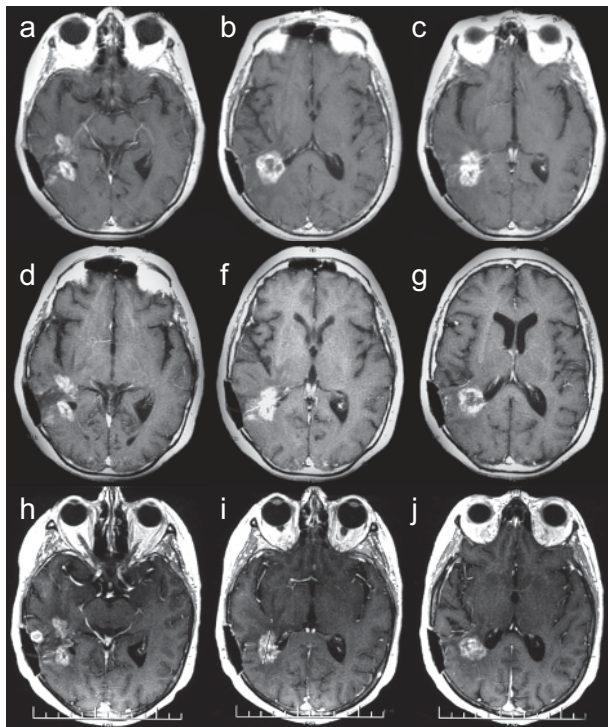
Brain MRI studies of patient 17. At time of inclusion, gadolinium-enhanced sections (a–c) showed recurrence in the right temporal lobe. MRI performed 30 days (d–f) and 60 (g–i) days after administration showed a minor response at the site of injections. Reduction of surrounding edema was also noted (not shown). A small recurrence occurred on the external part of the temporal lobe (g).
